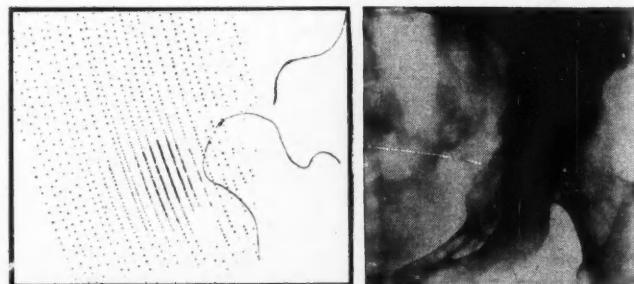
Radiograph of pelvis on right shows metastatic lesion in ilium and pubic ramus. This lesion was detected independently by scintigraphy as shown by the area of increased  $I^{131}$  uptake in the scan on the left.
